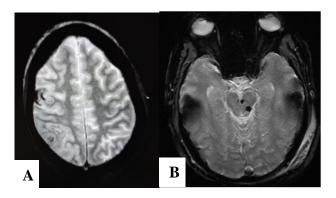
(A) and (B): MRI shows small foci of bleed suggests Diffuse Axonal Injury (DAI).
